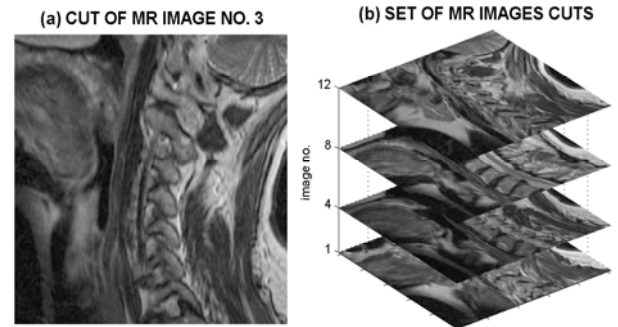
Real data standing for (a) a selected spinal MR image and (b) four chosen slices of these MR data set 3
